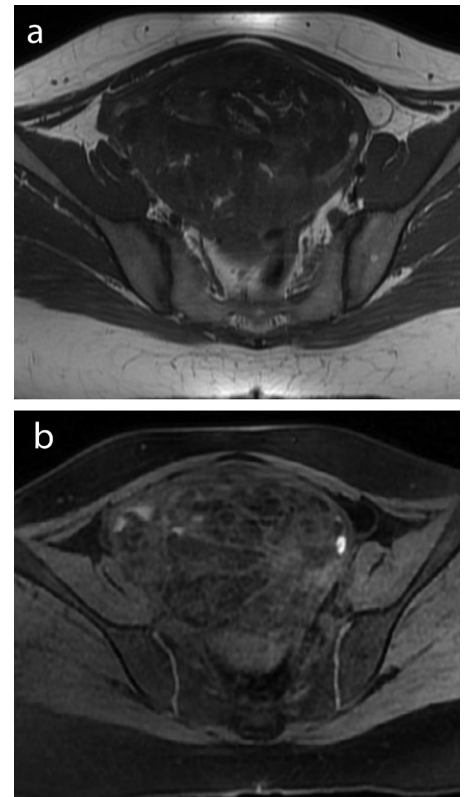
Axial T1WI (a) and fat-suppressed T1WI (b) revealing a large immature teratoma of the right ovary with small areas of fat. T1WI, T1-weighted imaging.
